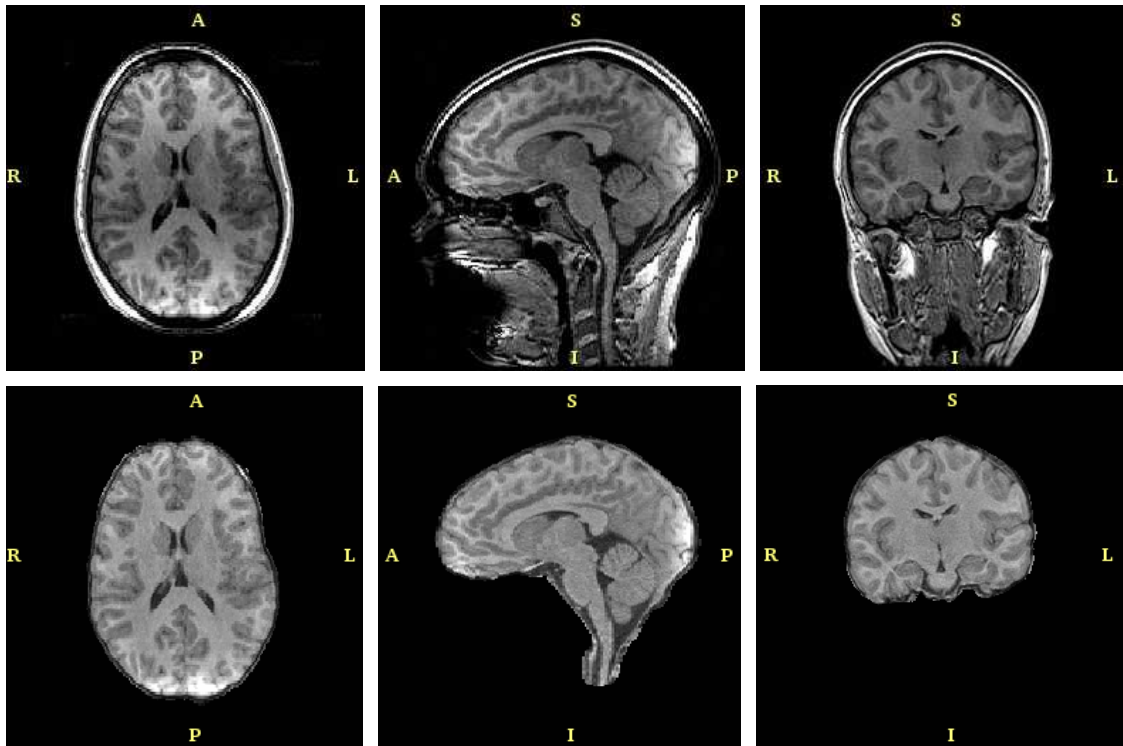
Skull-Stripped Cortical Volume. Top Row: Original T1-weighted MRI. Bottom Row: Skull-stripped cortical volume.
